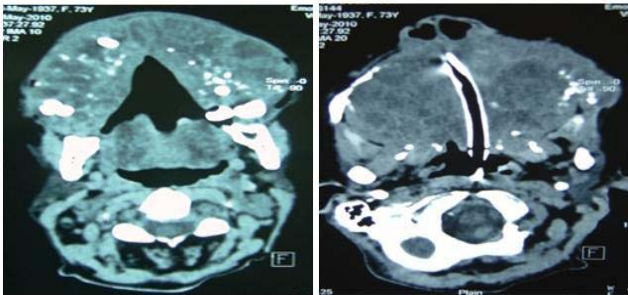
Axial view computed tomography scan.
